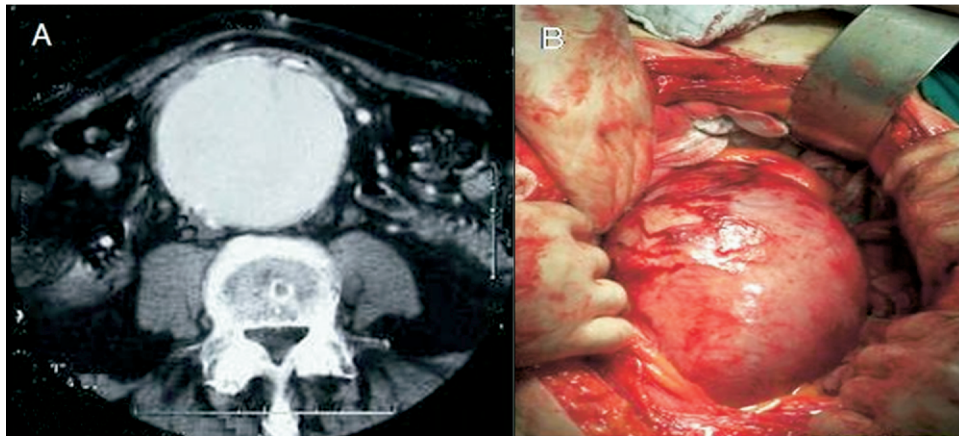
A, A computed tomography scan and (B) an intraoperative photograph show the giant abdominal aortic aneurysm in patient 1.
